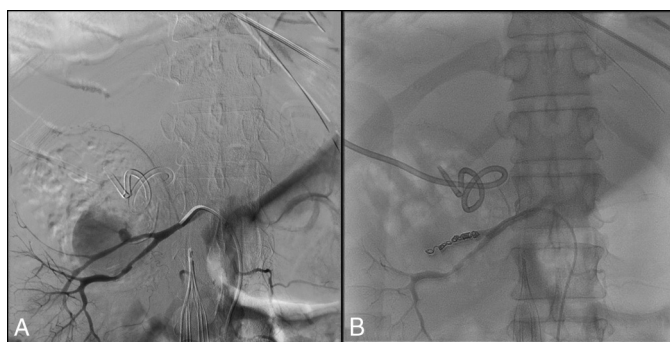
Radiograph film taken (A) during angiography showing the bleeding artery and (B) after coiling of the bleeding artery.
